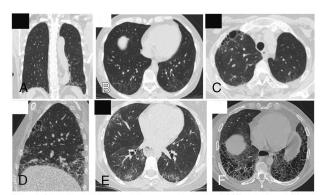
Selected images of high-resolution computed tomography (HRCT) signs. Coronal (A) and axial (B) HRCT images demonstrate straight edge sign. Axial (C) HRCT image represents anterior upper lobe sign. Sagittal (D) and axial (E) HRCT images depict four corners sign. Axial (F) HRCT images shows exuberant honexcombine sign.
